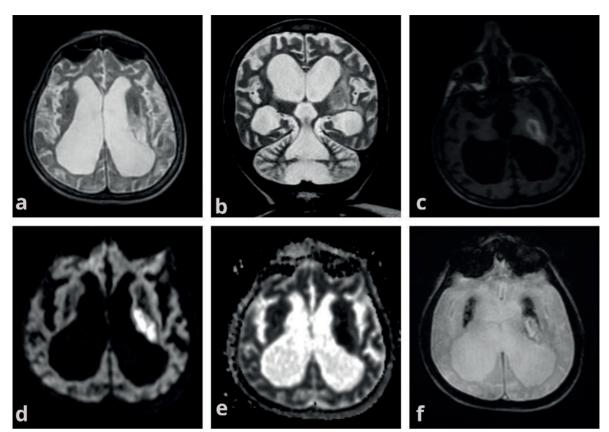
Magnetic Resonance Imaging demonstrated diffuse cerebral and cerebellar atrophies with ventricular dilatation, and widened sulci, volume loss of brain stem on T2 weighted images (a,b). On T1 weighted images, there was high signal intensity on the posterior limb of the left internal capsule and thalamus which suggested subacute hemorrhage (c). Diffusion-weighted images revealed restricted diffusion on the posterior limb of the left internal capsule, thalamus, and posterior periventricular area with a decrease in the ADC value (d,e). Gradient echo imaging showed small areas of hypointensity in basal ganglia suggesting calcification (f).
